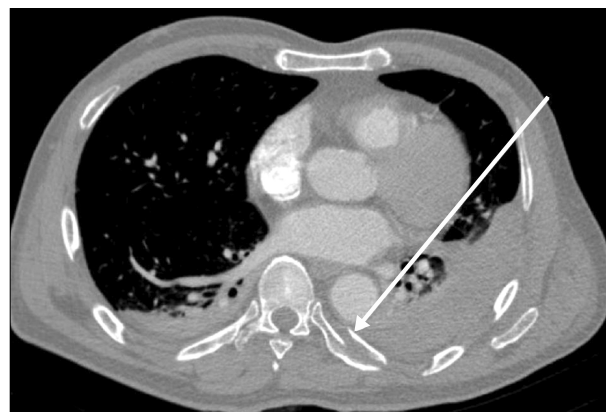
Follow-up chest computed tomography, 4-post trauma day. Increased hemothorax (arrow: fractured fragment of 7th rib, nearly same plane to Fig. 1).
